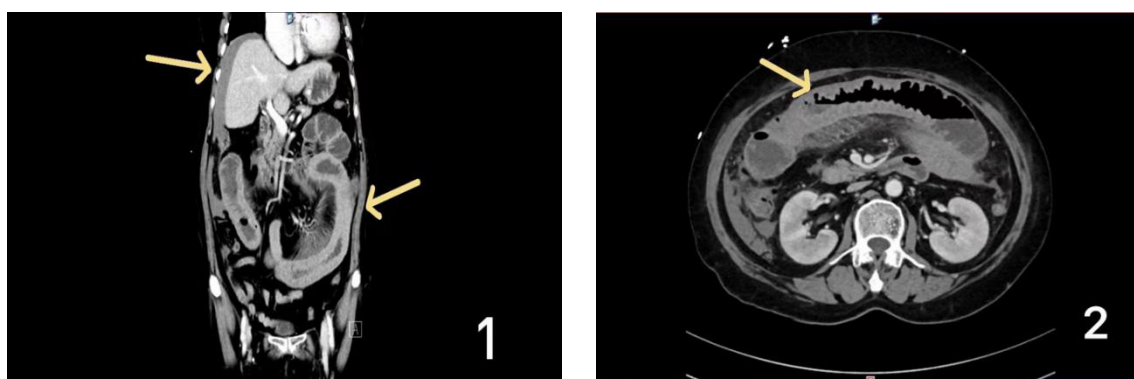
Computed tomography (CT) revealed segmental and uniform thickening of the proximal wall of the jejunum, which was significantly enhanced after enhancement.
